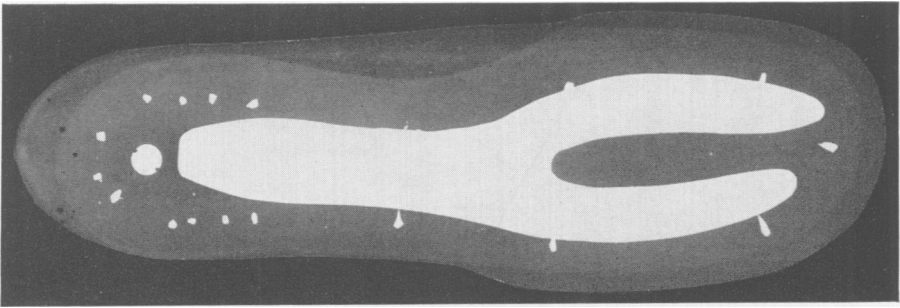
An anteroposterior roentgenographic view of the specially constructed shoe worn by the patients who had all their toes amputated for extensive tophaceous deposits. Note the forked shank of steel which is incorporated in the sole of the shoe. The shank is almost as long as the foot before amputation of the toes. This permits a spring to the patients' gait which otherwise would be lacking.
